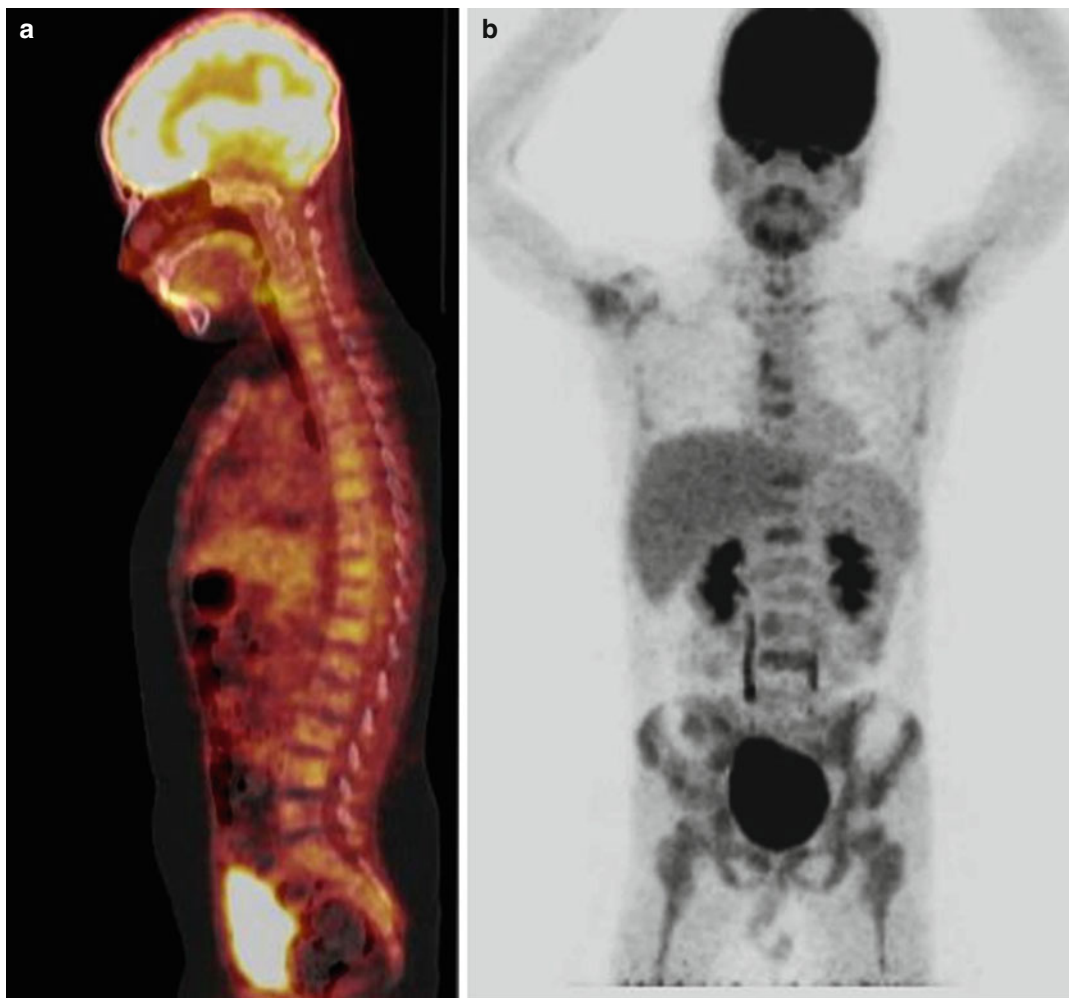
Sagittal PET/CT image (a) shows sclerotic lesions with increased FDG uptake in cervical, thoracic and lumbar vertebrae (SUV_{max} 3,5). MIP images of the body (b) and of the legs (c) show the extent of the disease
